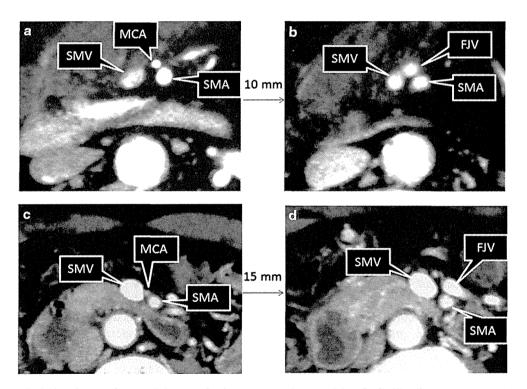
CT images displaying the vessels around the mesoduodenum in patients whose FJV was anterior to the SMA. Each *pair of panels* (a and b), (c and d) are images of the same person. (a, c) show
